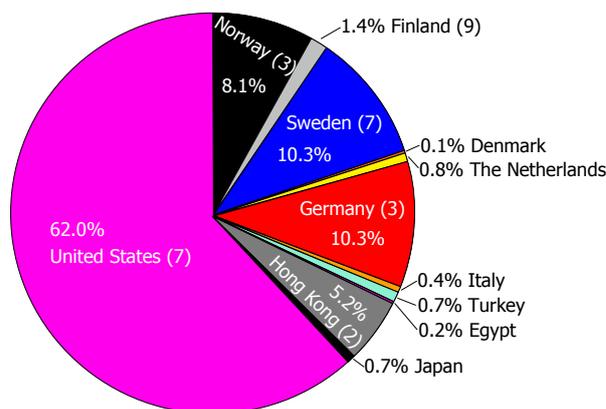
Shares of patients in the 37 evaluated studies with respect to the country of origin: The number of contributing studies is noted in brackets behind the country. Preponderance of United States is due to two reports of “mass X-ray evaluation” in the years 1977 and 1982. If these two are left out of consideration the median value of studied subjects in a paper is 212 (mean = 485).
